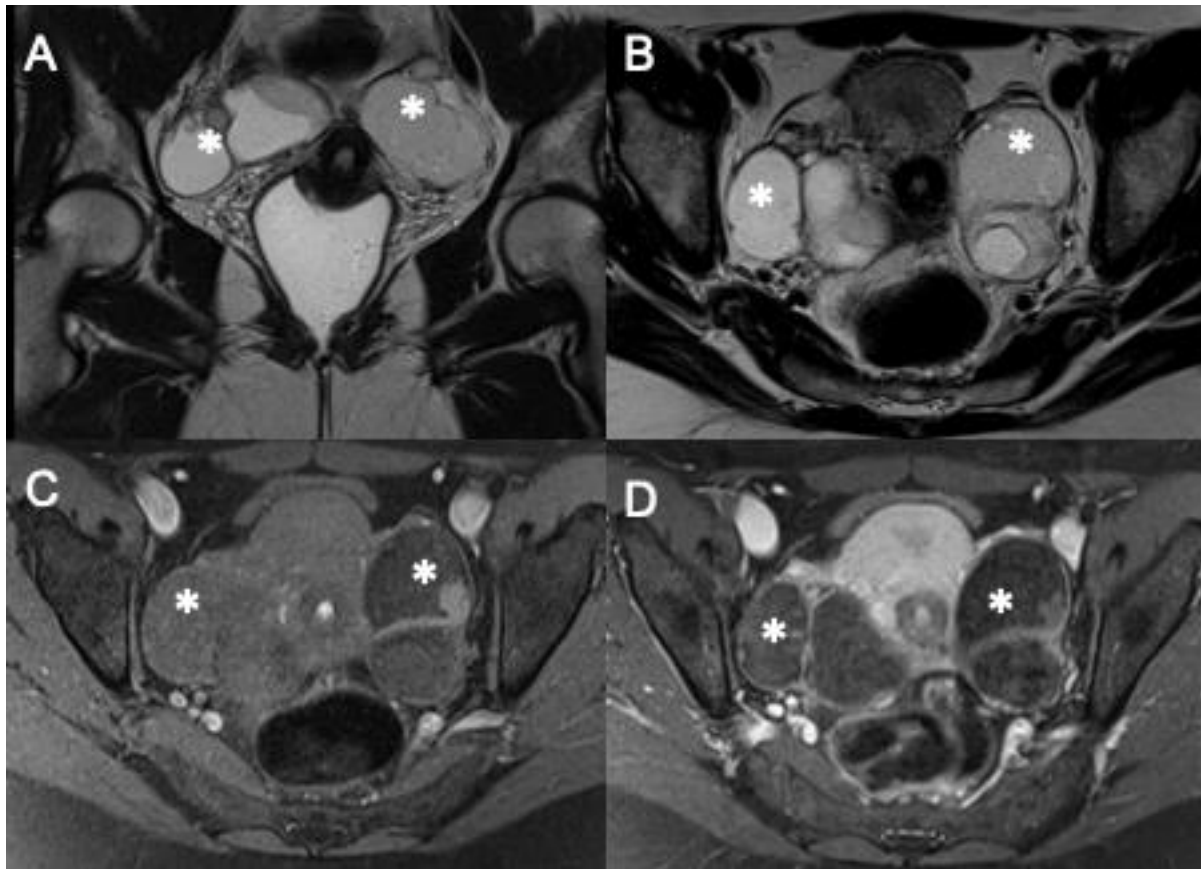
MRI of bilateral MCT: both ovaries show bilobed cystic lesions (asterisks) with component hyperintense on T2-weighted images (A, B) that lose signal on T1-fat suppression weighted imaging (C, D).
